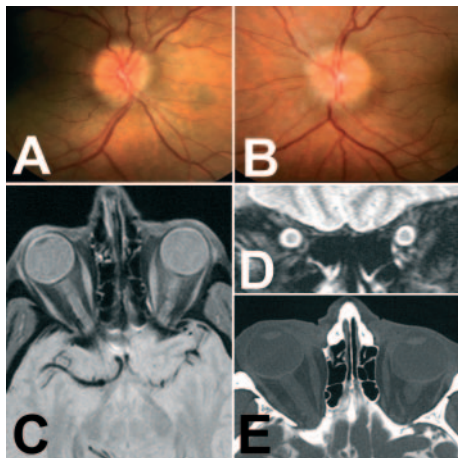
(A and B) Asymmetric papilloedema, more pronounced in the left eye. (Note obscuration of the vessels on the nasal disc). (C) Axial MRI T₁ sequence, displaying congested optic nerve sheath on both sides and flattening of the posterior sclera. (D) Coronal orbital MRI, T₂ sequence demonstrating fluid accumulation and dilatation of both SAS of the optic nerves. (E) CT cisternography. CLCSF in the intracranial CSF spaces. No CLCSF in both SAS of the optic nerves.
